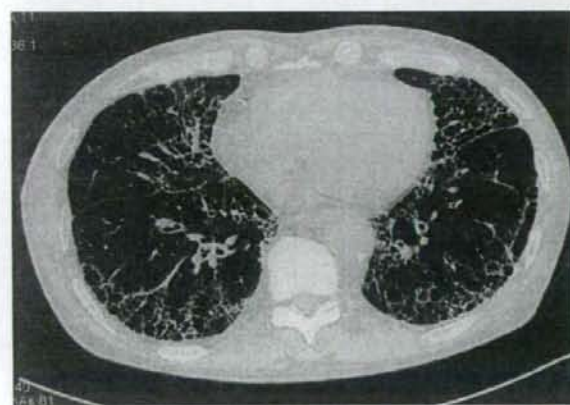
Chest CT from July 2001. Bilateral reticular abnormality and honeycombing are observed in the lower lobes.
